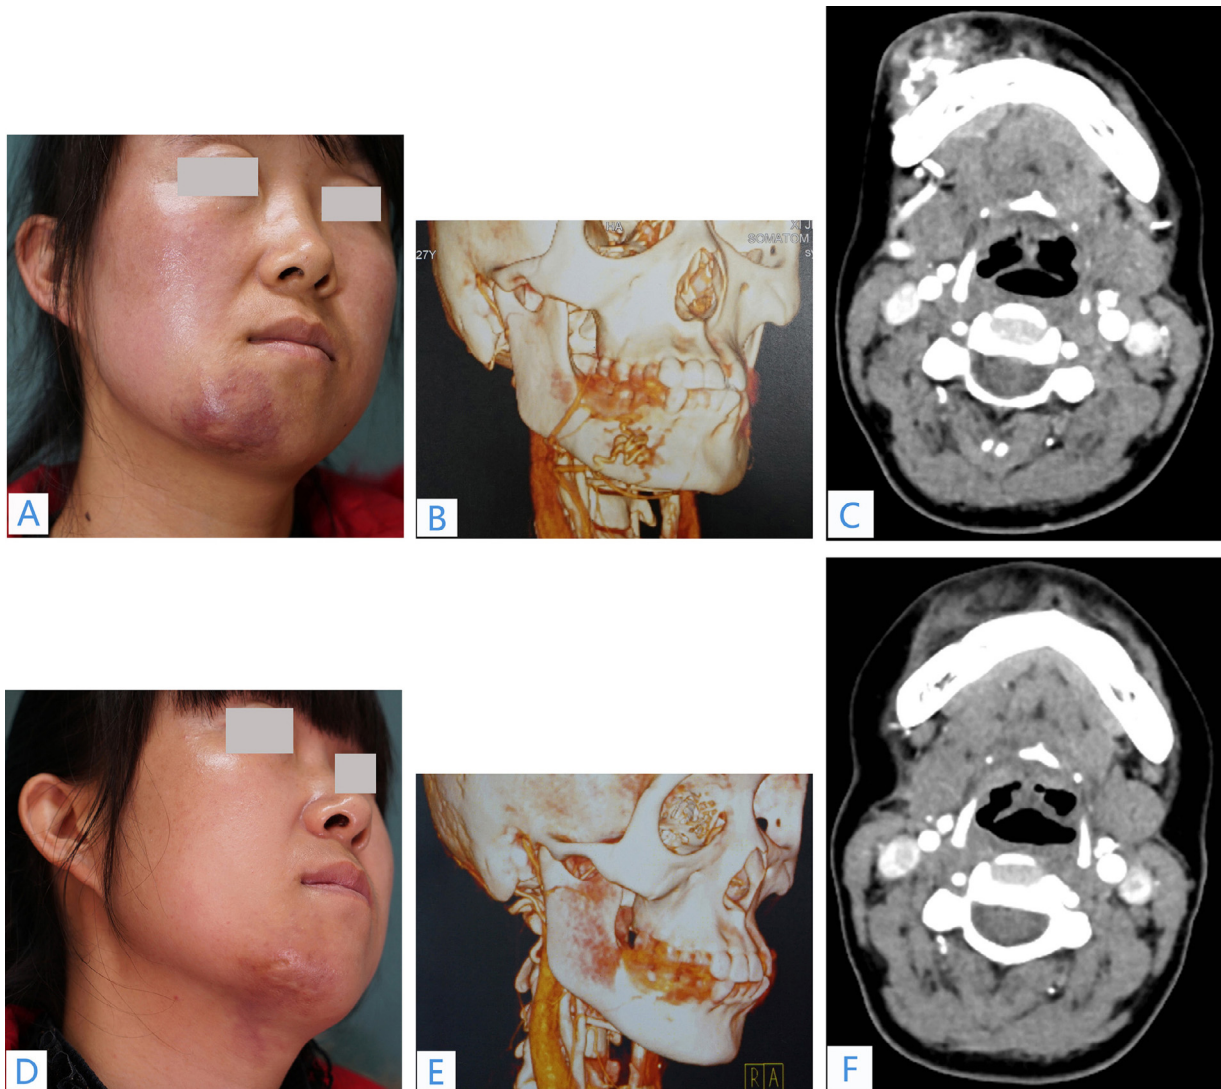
Arteriovenous malformation (AVM) in the chin. Facial appearance, 3-dimensional computed tomography angiography (3-D CTA) and computed tomography (CT) scans before treatment (A, B, and C); Facial appearance, 3-D CTA, and CT scan after treatment (D, E, and F).
